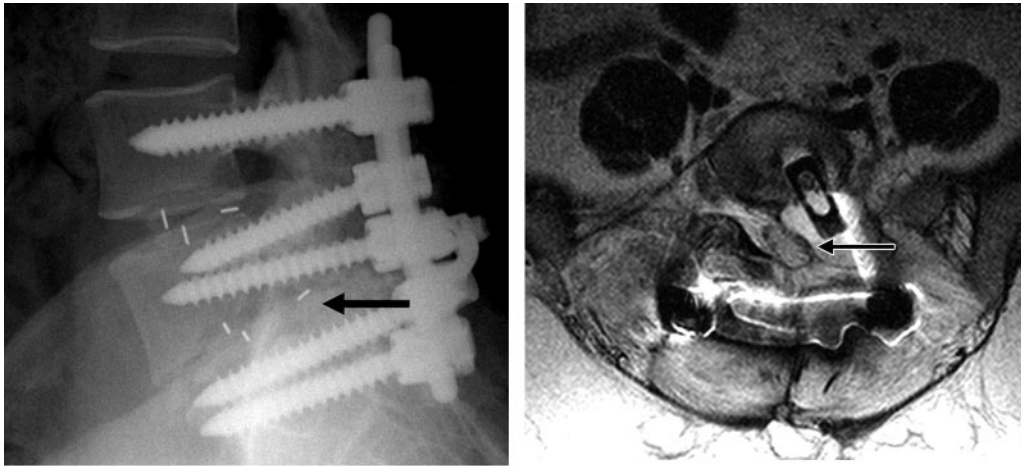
Dorsal herniation of an intervertebral bone graft cage in a 41-year-old woman with acute neuropathy. (a) Lateral radiograph depicts posterior interbody fusion at L4–5 and L5–S1 and posterolateral displacement of the L5–S1 bone graft cage into the spinal canal (arrow). The patient was experiencing worsening low back pain and a left L5 radiculopathy. (b) T2-weighted MR image demonstrates ventral and lateral effacement of the thecal sac (arrow) by the cage.
